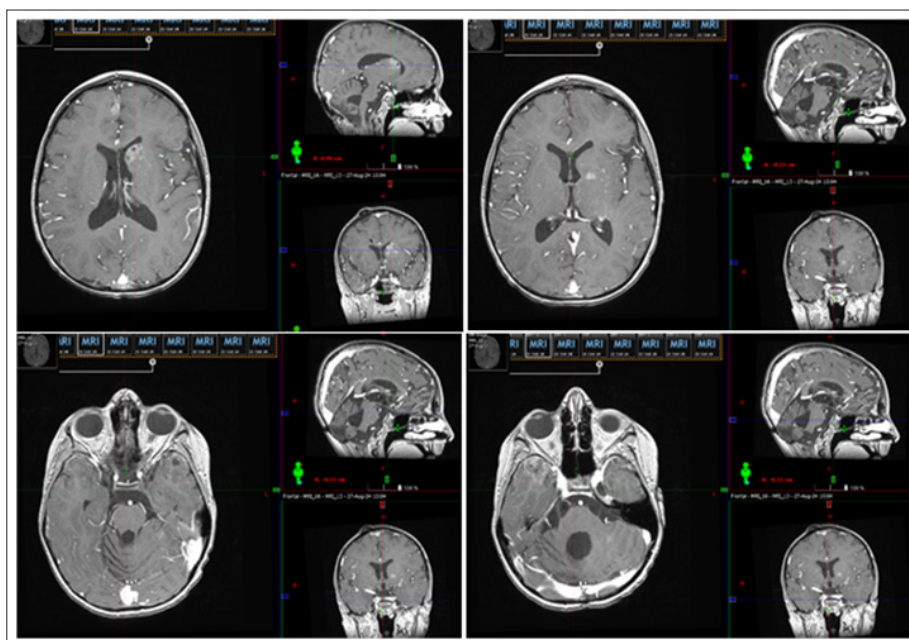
The Control Brain MRI on 27.08.24 Revealed Progression of the Leptomeningeal Disease
